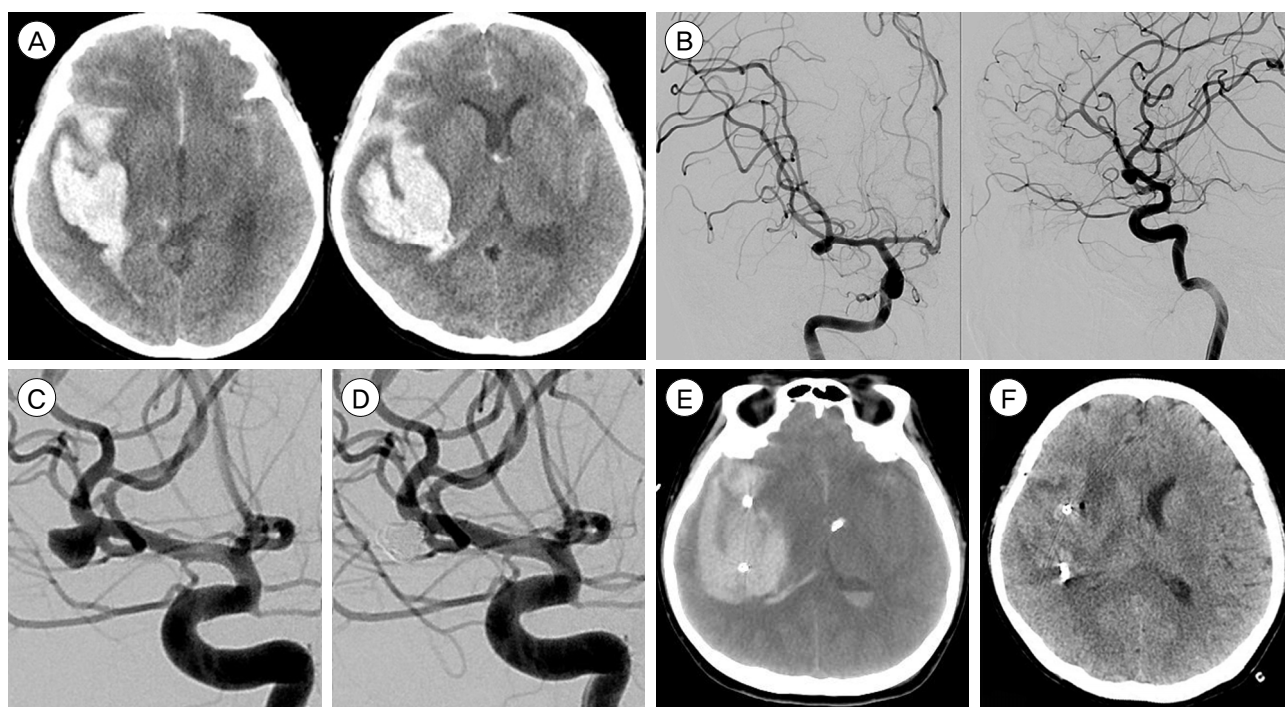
A 41-year-old female patient with ruptured right MCA aneurysm. (A) Brain CT scan revealed a diffuse subarachnoid hemorrhage and a large ICH and ISH in the right perisylvian area, with an estimated volume of 55 mL. (B) brain CTA and DSA revealed a 5 mm ruptured right-MCA aneurysm. (C-F) She underwent endovascular coil embolization using 6 coils (C: preoperative, D: postoperative), which was followed by SRH using urokinase (E: postoperative, F: postoperative 14 days). MCA = middle cerebral artery; ICH = intracerebral hemorrhage; ISH = intrasylvian hemorrhage; CTA = CT angiography; DSA = digital subtraction angiography.
